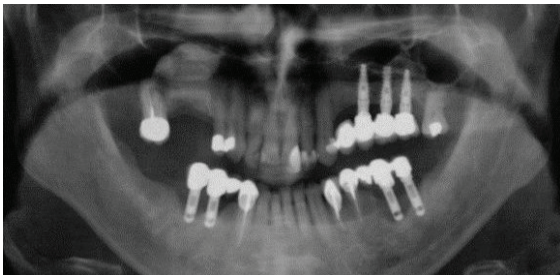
Panoramic radiograph taken 6 months after sinus floor augmentation and interpositional grafting showing excellent consolidation with well-defined contours of the fragment and the augmented sinus floor showing more than 20 mm of bone height.
